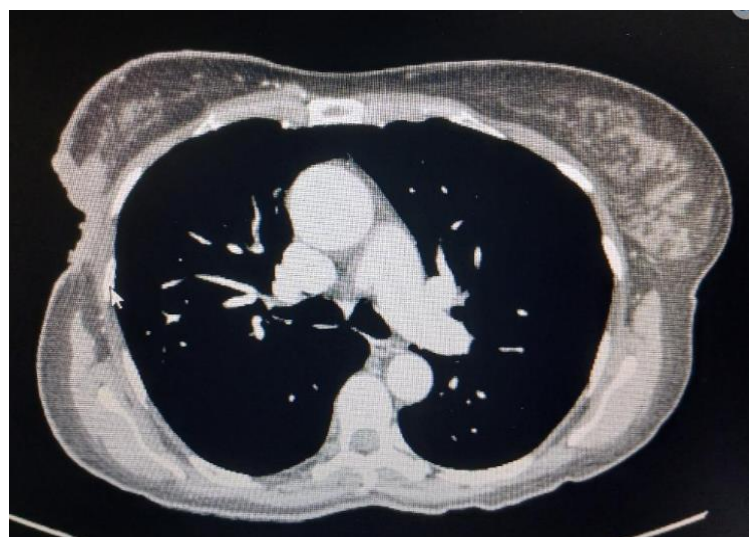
CT scan showing ulcerating upper outer quadrant right breast cancer with pectoralis major muscle infiltration from the patient shown in Figure 1A.
